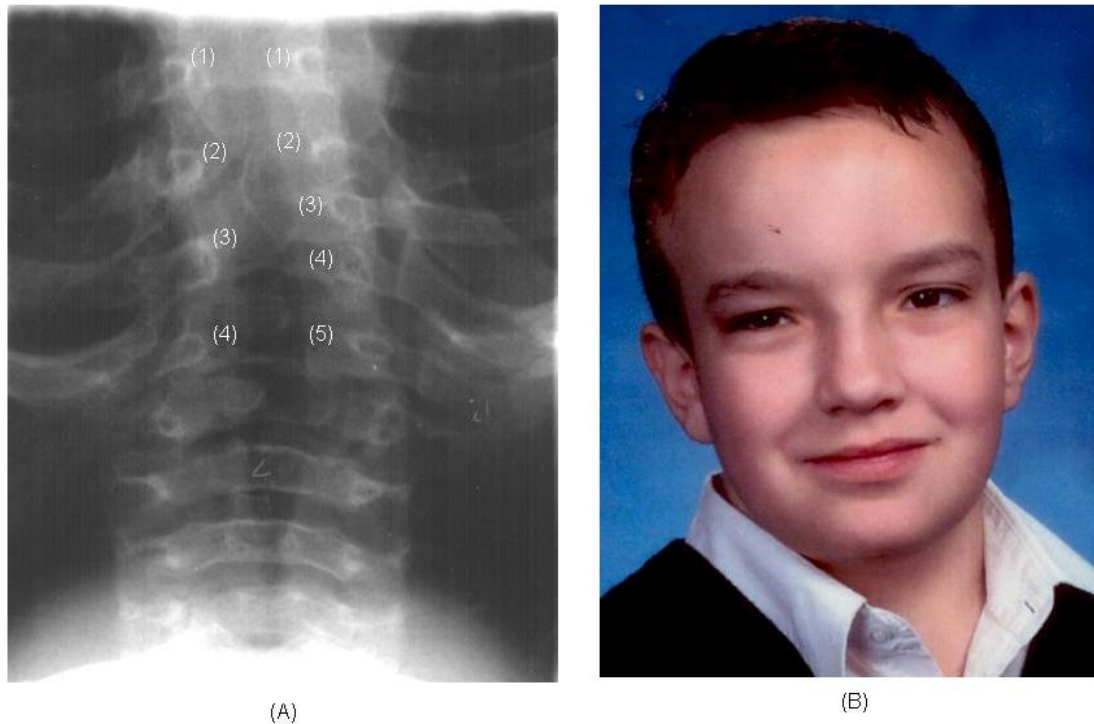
(A) chest X-ray image of patient taken at 4 years of age, showing the left extra rib, (B) Facial photograph of patient at 11 years of age.
